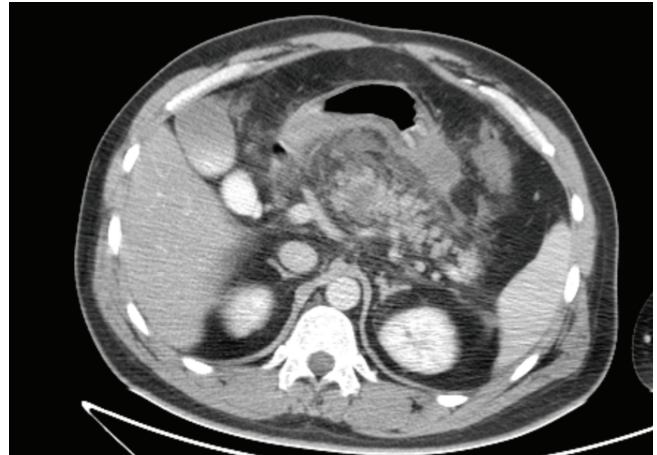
Admission CT scan of a patient who underwent non-operative treatment.
